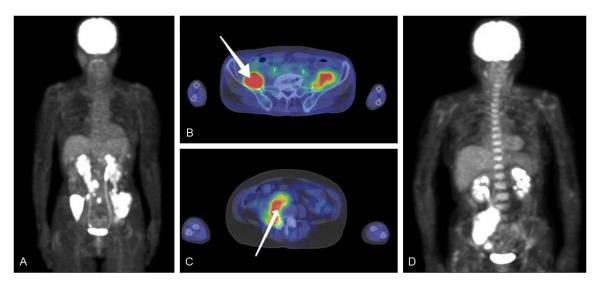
FDG-PET/CT detected diffuse high uptakes in the iliacus muscles. A: Coronal maximum intensity projection image of PET in Case 1. B: Cross-sectional imaging of FDG-PET/CT in Case 1. Added white arrow shows the position of needle on CT-guided biopsy. C: Cross-sectional imaging of FDG-PET/CT in Case 2. Added white arrow shows the position of needle on CT-guided biopsy. D: Coronal maximum intensity projection image of PET in Case 2.
